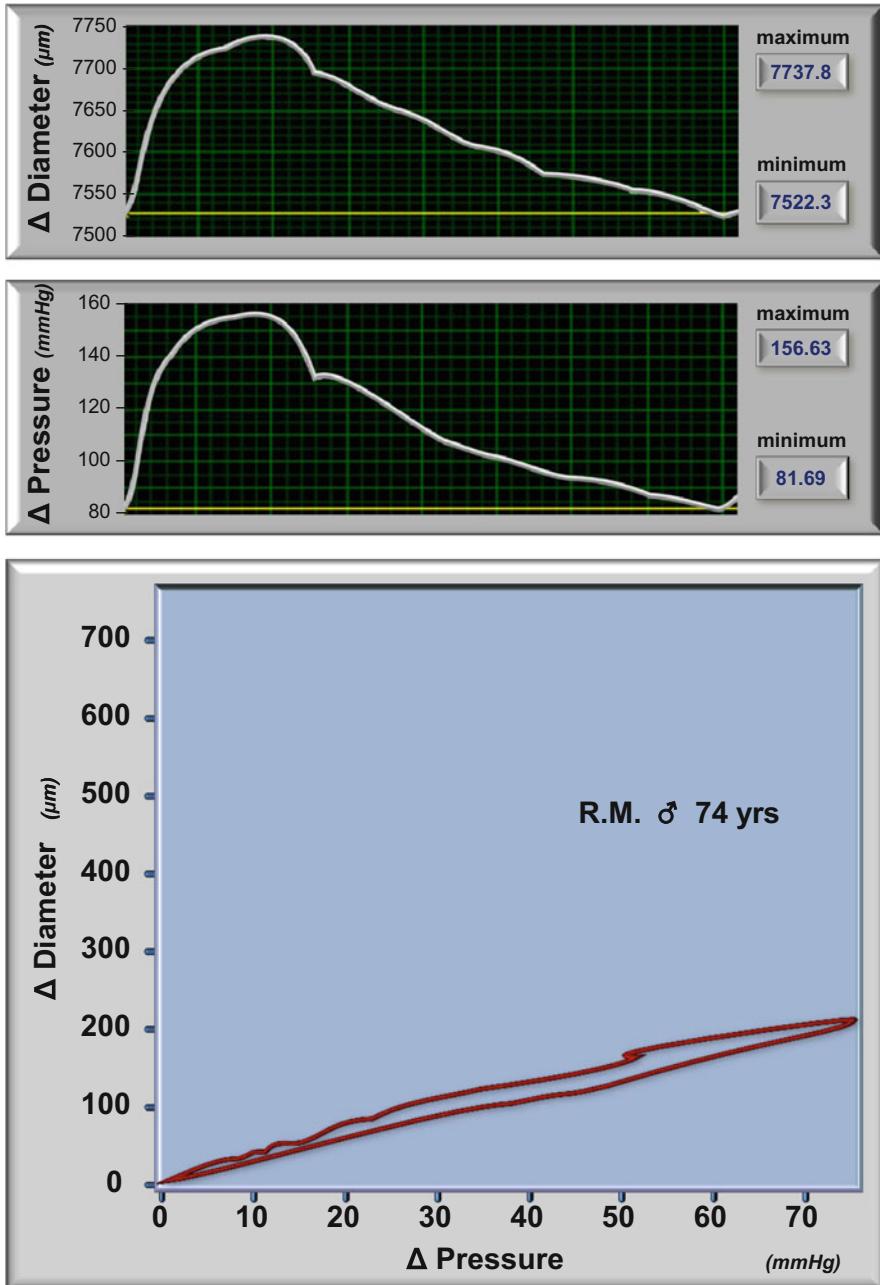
Wall Track System: assessment of the arterial diameter change during a cardiac cycle by means of an ultrasound device
